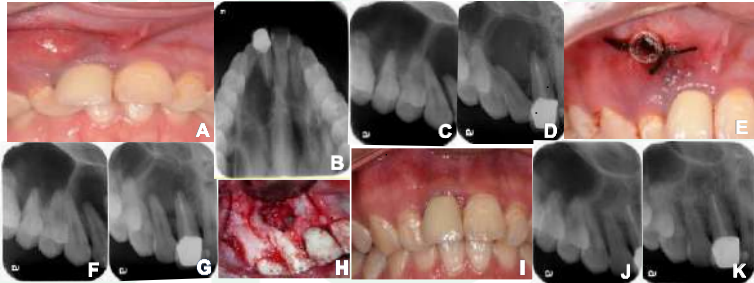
(A) Localized swelling above UR1 and UR2. (B) The maxillary occlusal radiograph. (C, D) The preoperative radiograph showed a radiolucent lesion involving the apices of UR1 and UR2. (E) A custom-fitted tube was sutured. (F, G) The periapical radiograph at the 3.5-month recall. (H) Flap reflection and lesion enucleation. (I) Soft tissues healed well at a six-month review. (J, K) The periapical radiograph at the 22-month recall.
